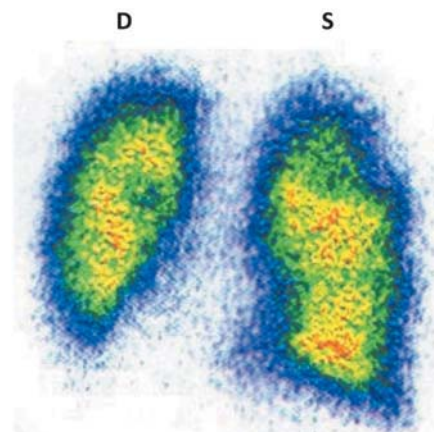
Pulmonary (perfusion) scintigraphy of the *patient C.*, performed on March 26, 2014. Deformed image of both lungs with uneven distribution of the radiopharmaceutical, with small foci of diminished pulmonary perfusion over the whole pulmonary surface
